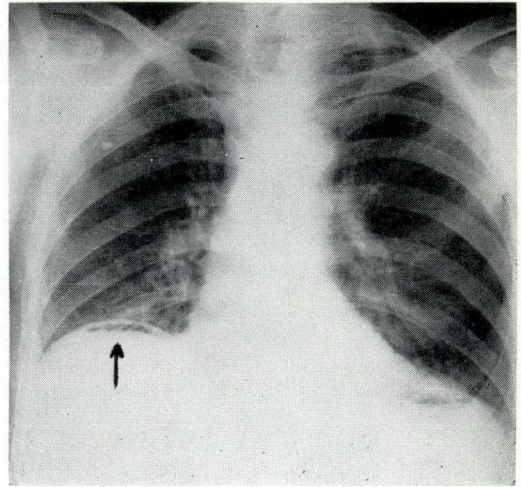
Case 4: Roentgenogram of the chest reveals free air beneath the right hemidiaphragm.
